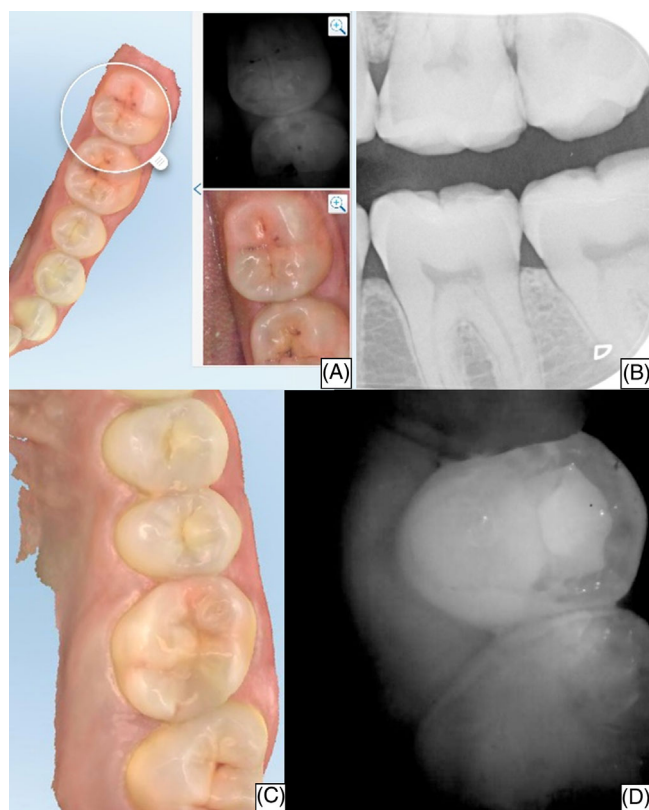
(A) A proximal (disto-occlusal) carious lesion on tooth 3.6 observed as involving dentinoenamel junction (DEJ) on near-infrared imaging (NIRI) screen. (B) The proximal lesion of 3.6 was scored as early-enamel-lesion on bitewing radiography. (C) A lesion involving DEJ in the mesial surface of tooth 2.6, IOS software has colored the region red. (D) NIRI image of the lesion involving DEJ in mesial surface of tooth 2.6.
